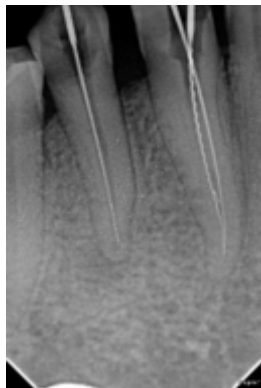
Working length X-ray
